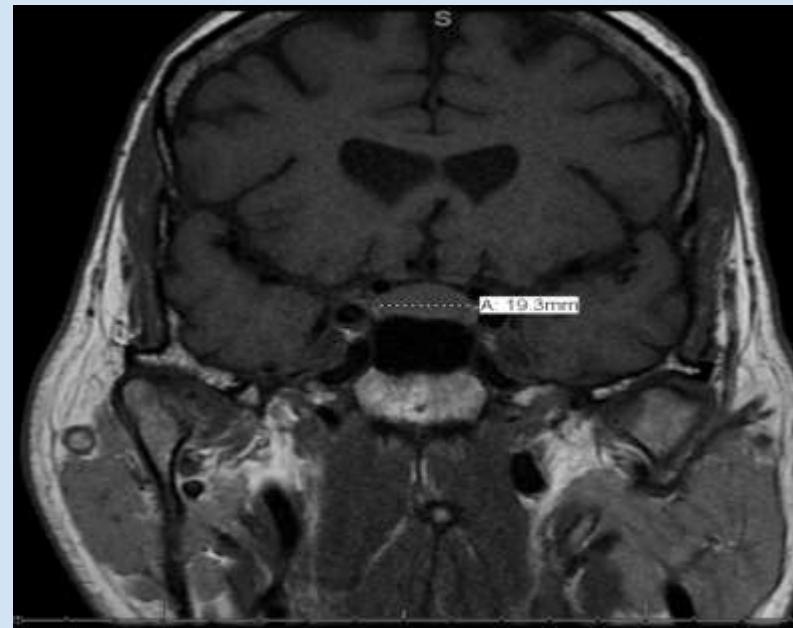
MRI Brain showing enhancement of pituitary gland in Coronal View
